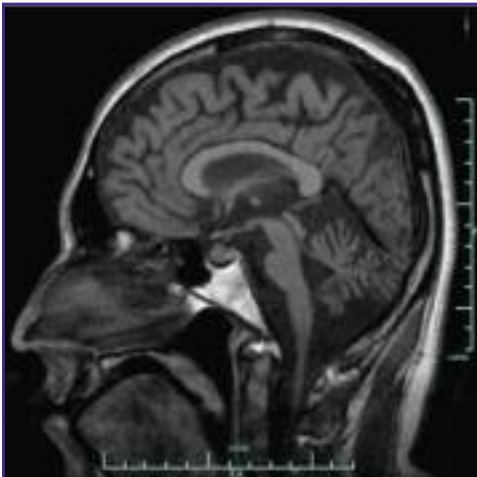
MRI brain T1 saggittal view showing generalized cerebral, marked cerebellar, and pontine atrophy
